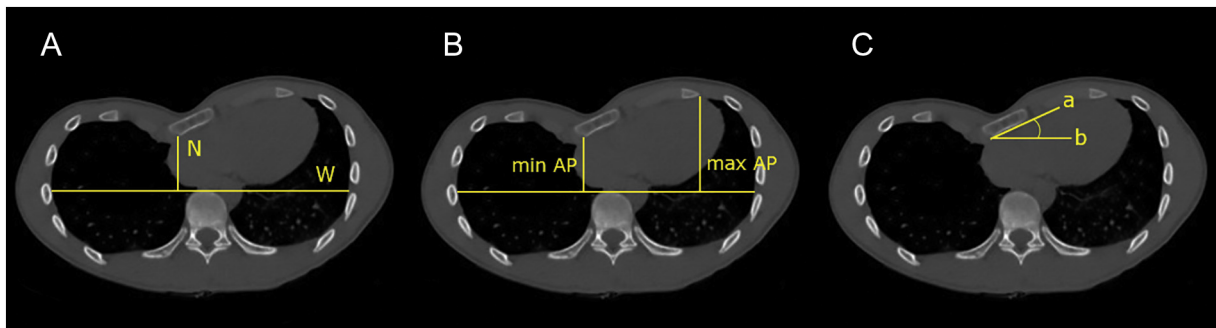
CT-CWI and STA. A: Haller Index =  $W/N$ . B: Correction Index =  $(\text{Max AP} - \text{Min AP}/\text{Max AP}) \times 100$ ; Sternal Torsion Angle: angle between line a and b.
